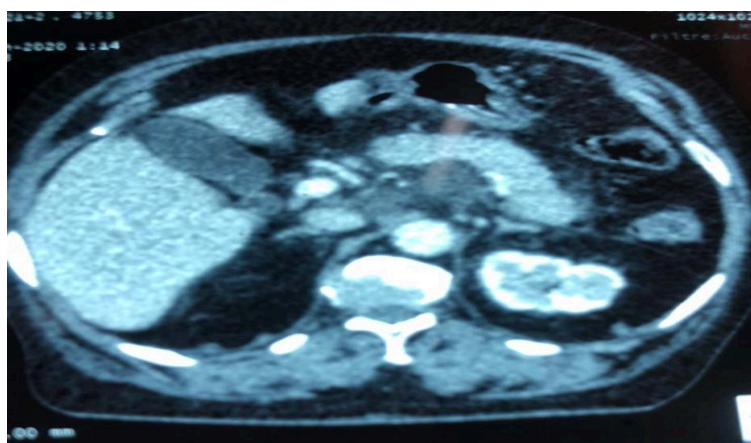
Abdominal CT scan acute pancreatitis findings reported in Case 1.
